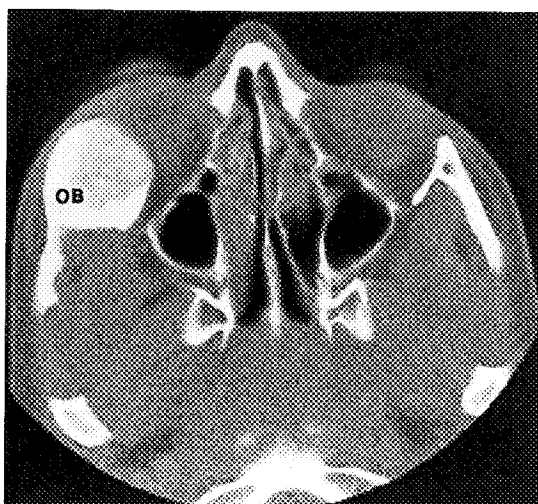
CT scan shows an osteoblastoma (OB) involving the lateral wall of the right orbit.
